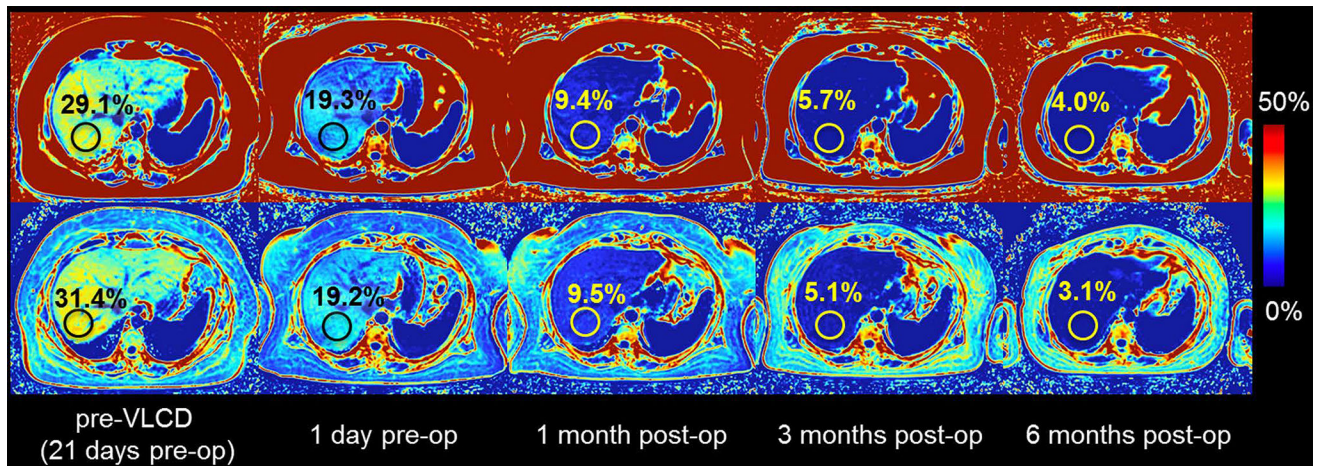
Longitudinal changes in MRI-PDFP after weight loss surgery
